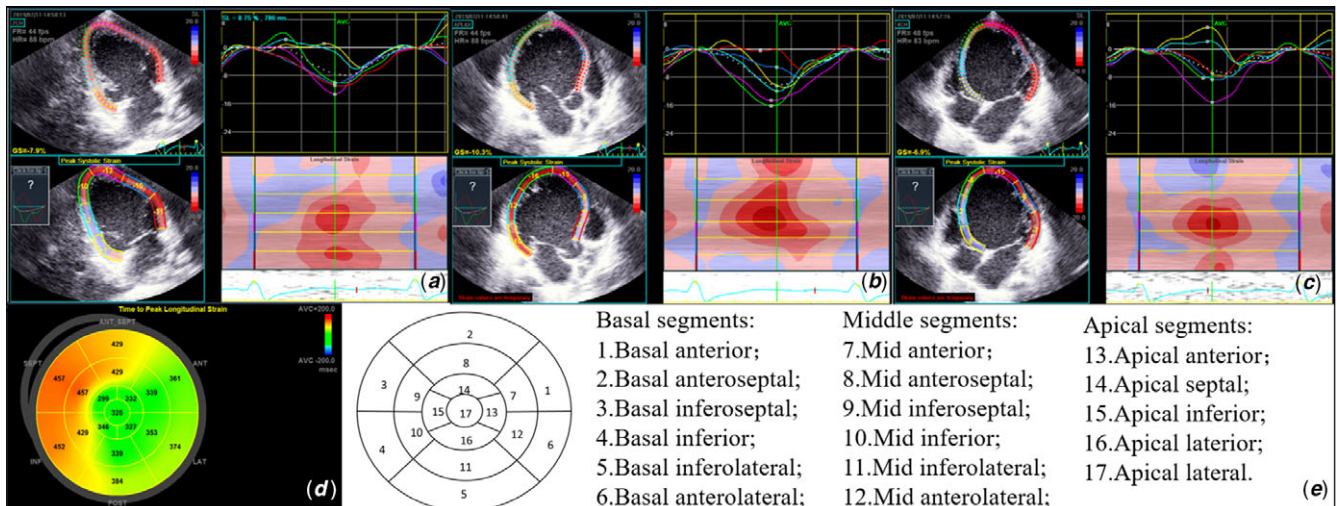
Strain-time curves of the left ventricular (LV) long-axis apical two, three and four chamber views measured via two-dimensional speckle tracking imaging in a patient with ventricular pre-excitation (VPE) related cardiac dysfunction. (a) Strain-time curves of the apical two-chamber view. (b) Strain-time curves of the apical three-chamber view. (c) Strain-time curves of the apical four chamber view. The strain value was positive (yellow and blue) at the septum and negative at all other segments. The septum presented diastole, while the other segments contracted; this phenomenon was interpreted as ventricular septal dyssynchrony (classical pattern). (d) The bull's-eye plot of the LV time-to-peak systolic strain (Ts) shows a delayed ventricular septal Ts (yellow) and dyssynchrony of the other segments in LV (green). (e) The bull's-eye plot shows the sections of the left ventricle.
